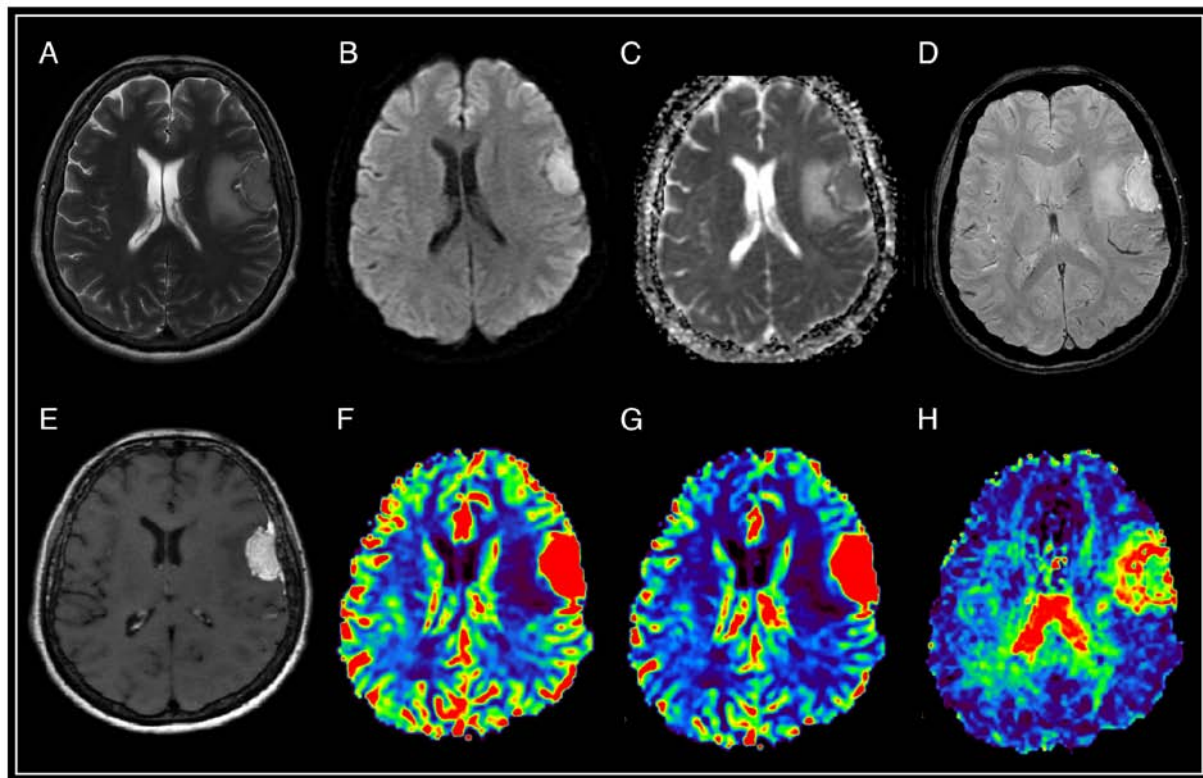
Brain magnetic resonance imaging of a patient with atypical meningioma (WHO Grade 2). In the frontal region of the left hemisphere, against the background of perifocal edema, an extracerebral tumor is visible with an intense and homogeneous accumulation of a contrast agent, the 'dural tail' phenomenon, diffusion limitation, an increase in volumetric and velocity cerebral blood flow, and a prolongation of blood transit time. The SWAN demonstrates the presence of peripheral draining veins around the mass. (A) T2-WI; (B and C) DWI and ADC; (D) SWAN; (E) T1-WI with contrast; (F) CBV; (G) CBF; and (H) MTT. SWAN, susceptibility-weighted angiography; T1-WI, T1-weighted image; T2-WI, T2-weighted image; DWI, diffusion-weighted imaging; ADC, apparent diffusion coefficient; CBV, cerebral blood volume; CBF, cerebral blood flow; MTT, mean transit time.
